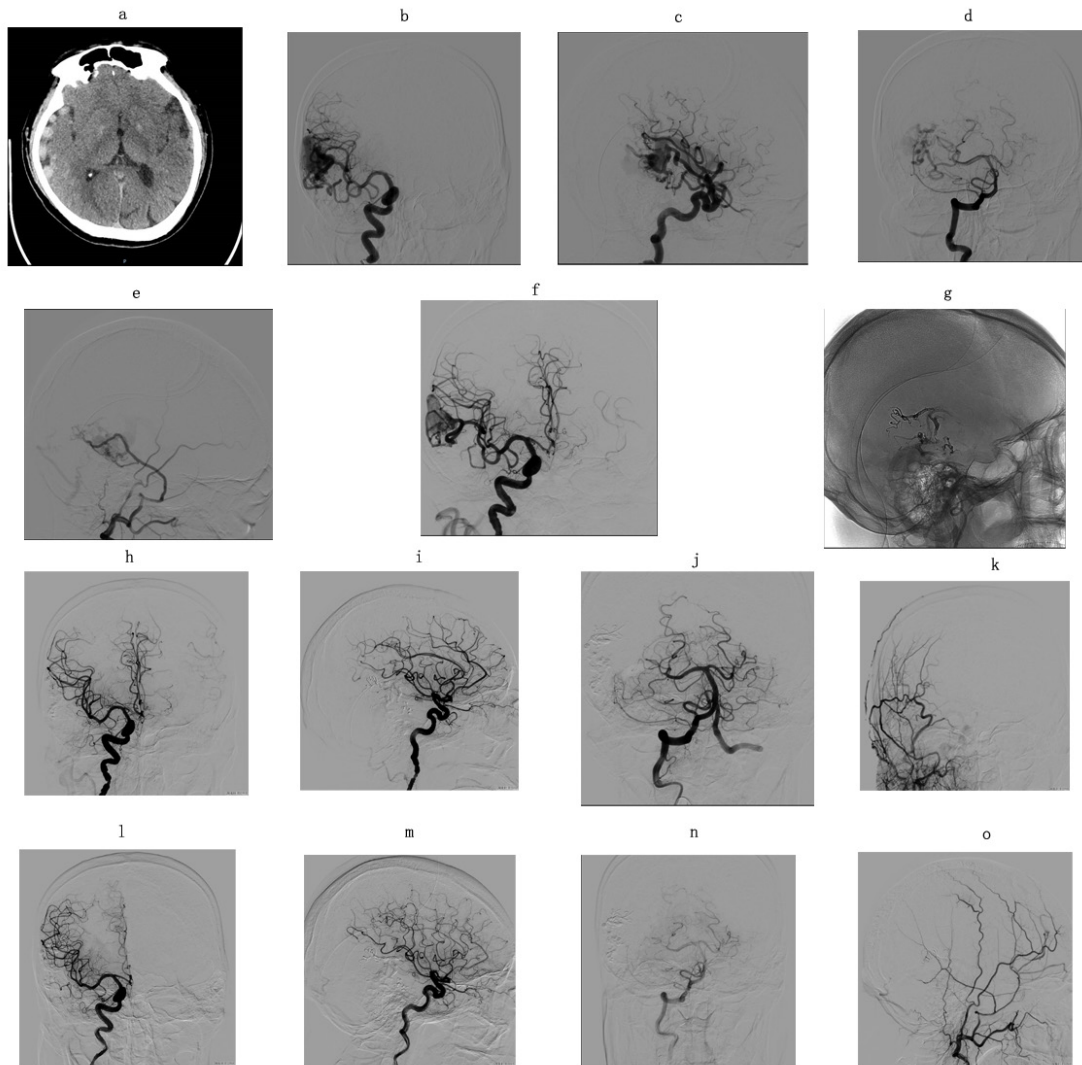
CT demonstrated a hyperdense lesion in the right temporal lobe (a). Pre-operative DSA revealed that the AVM arterial feeders are the right middle cerebral artery, internal maxillary artery, and posterior cerebral artery (b-e). Right internal carotid artery (ICA) angiography showed that the AVM was partially embolized (f, g). Post-operative DSA revealed complete obliteration of the residual AVM three months after surgery (h-k). Follow-up DSA reconfirmed occlusion of the AVM three months after spontaneous regression (l-o).
